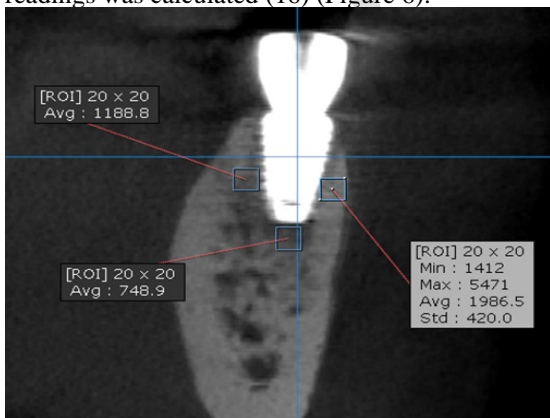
Radiographic bone density evaluation.
